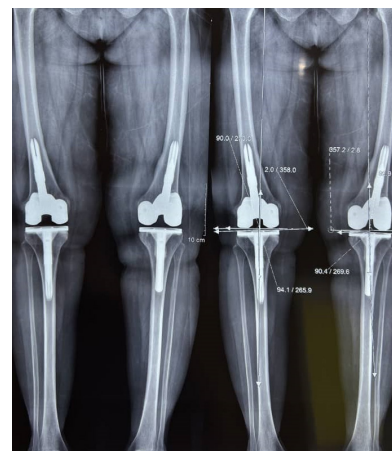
The radiographs showed a well-located knee prosthesis in situ without any sign of fractures post-operatively.
